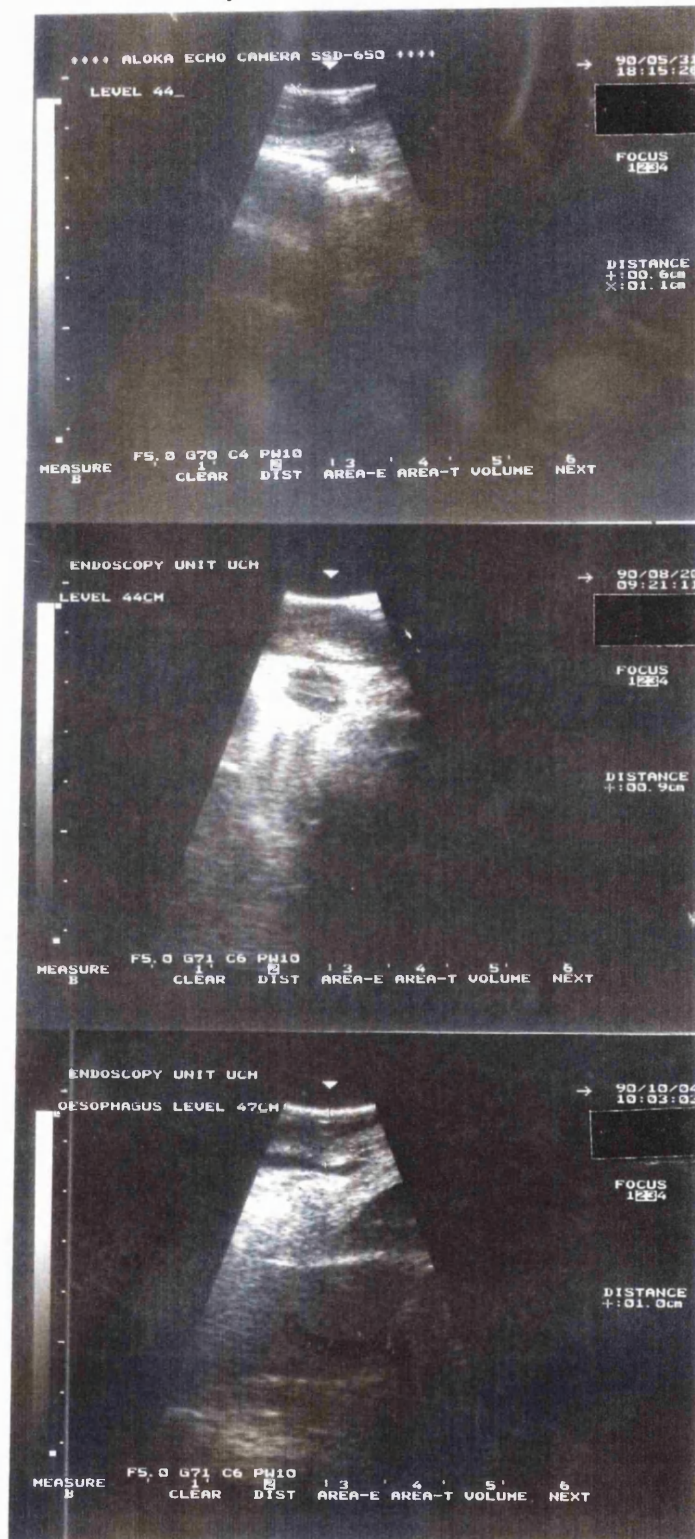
A i Sequential endoluminal ultrasound images
